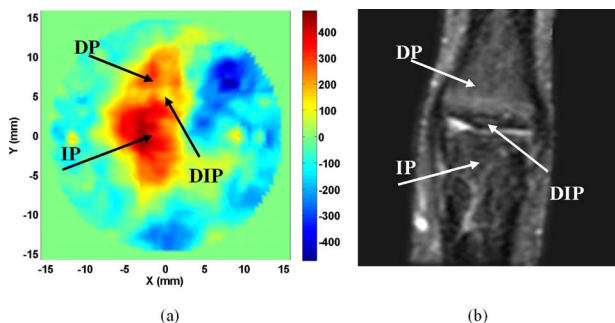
Selected coronal section from the reconstructed 3-D image (absorbed energy density) at $z=-5$ mm (a), and MRI (coronal section) from a similar joint (b). DP: distal phalanx; IP: intermediate phalanx; DIP: distal interphalangeal joint.
